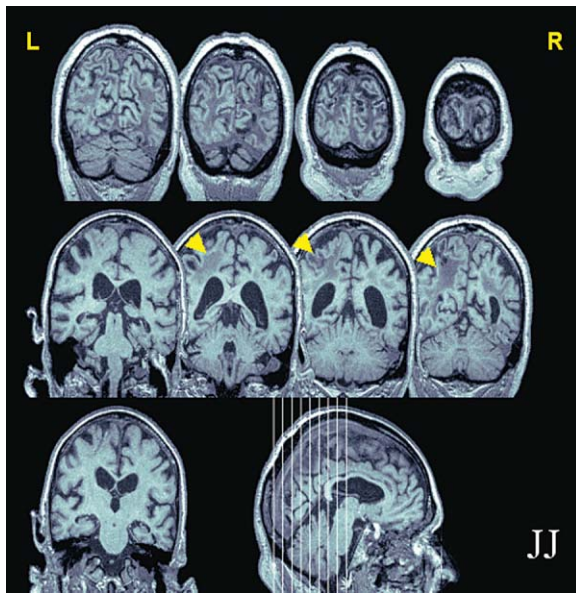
JJ Structural MRI Scan
